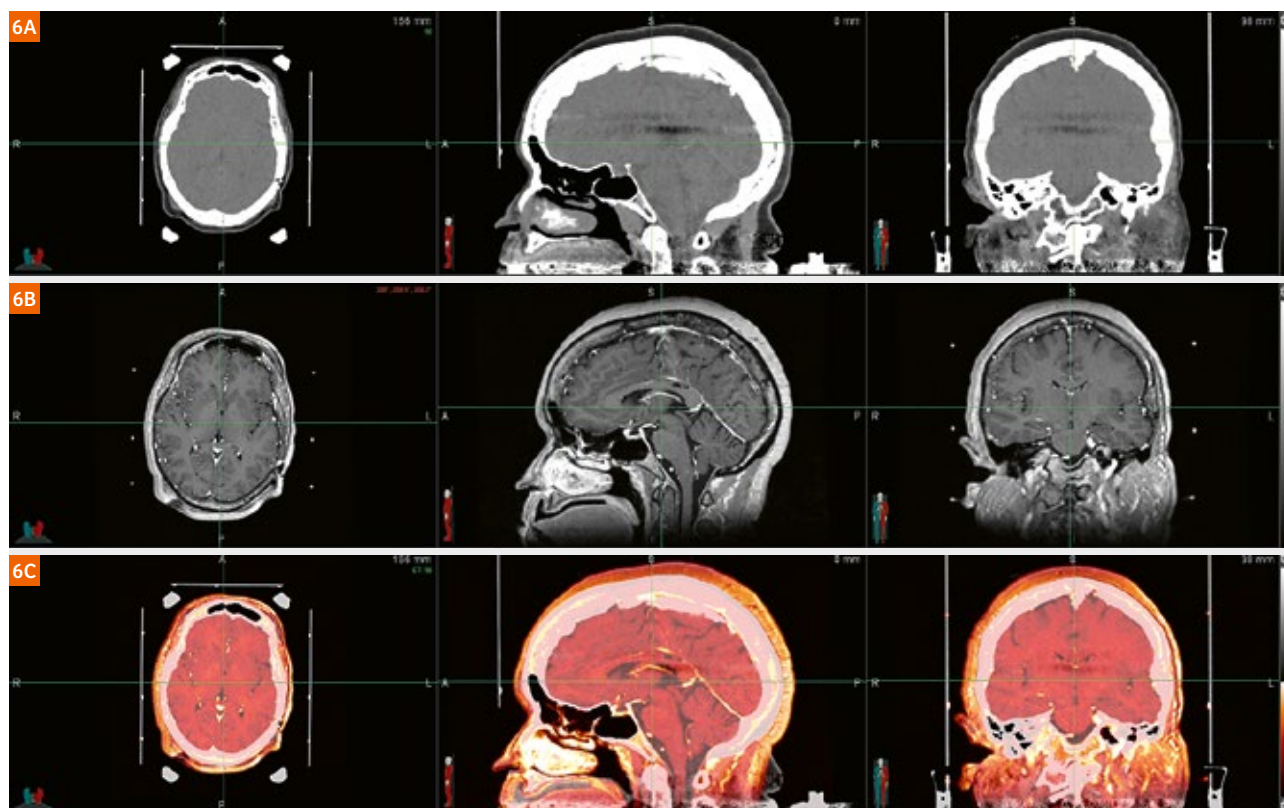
Patient corrected MRI images fused with CT images. (6A) CT image, (6B) corrected MRI images, (6C) fused MRI and CT images.
